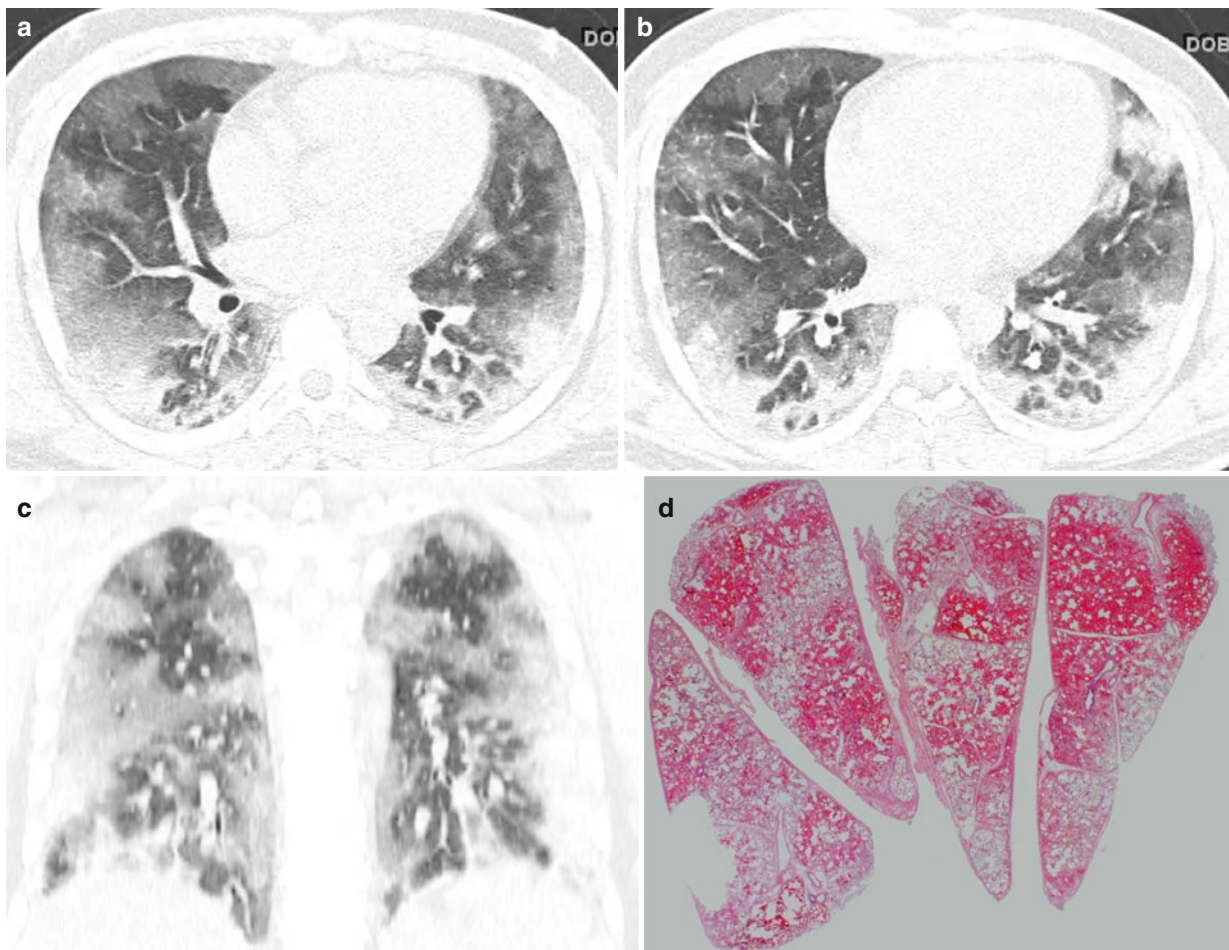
Diffuse alveolar hemorrhage in a 27-year-old man without specific underlying disease identified. (a, b) Lung window images of CT scans (2.5-mm section thickness) obtained at levels of right middle lobar bronchus (a) and segmental bronchi (b), respectively, show diffuse areas of parenchymal opacity (consolidation and ground-glass opacity) in both lungs. (c) Coronal reformatted image (2.0-mm section
